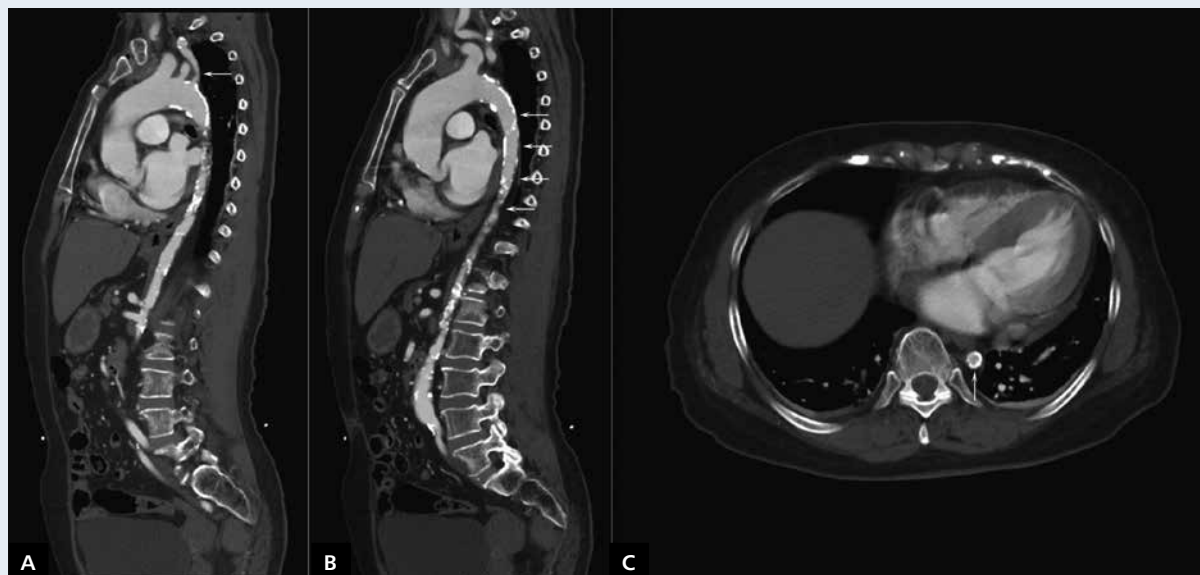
Computed tomography angiography of aorta; A. Stenosis of left subclavian artery; B, C. Severe descending aortic stenosis, with extensive collateralisation between subclavian artery and arteria iliaca externa
